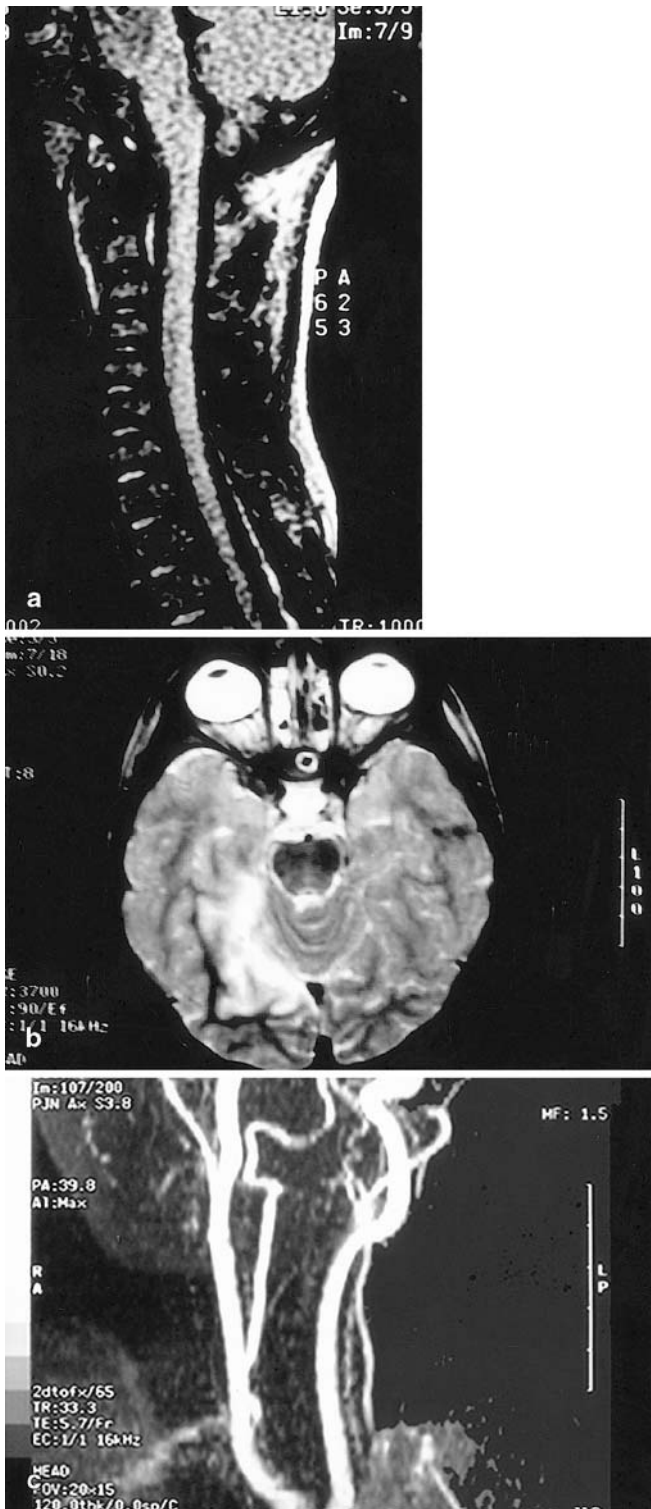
Representation of the radiologic findings in patient 2. a Cervical MRI demonstrating a C2 fracture without spinal cord compression. b MRI diffusion-weighted image showing the right posterior cerebral artery territory infarction. c MRA of the cervical vessels, demonstrating the presumed vertebral artery dissection.
